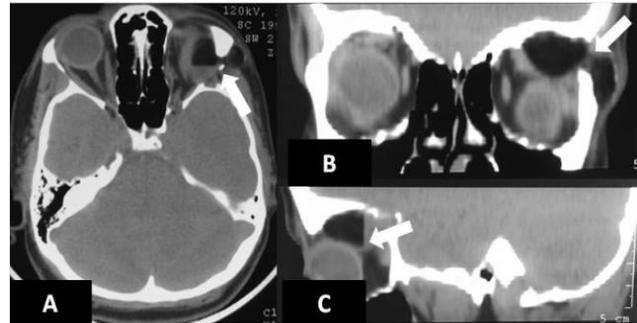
An orbital CT examination without contrast in consecutive images (A-C) show a macrolobular lesion of equal or less density as the fat tissue, which had a component that extended to subcutaneous fatty tissue by separating zygomatico-frontal suture laterally (white thick arrows). The lesion shows fat-fluid leveling. The lesion mildly compresses superior rectus muscle and the bulbus oculi.
